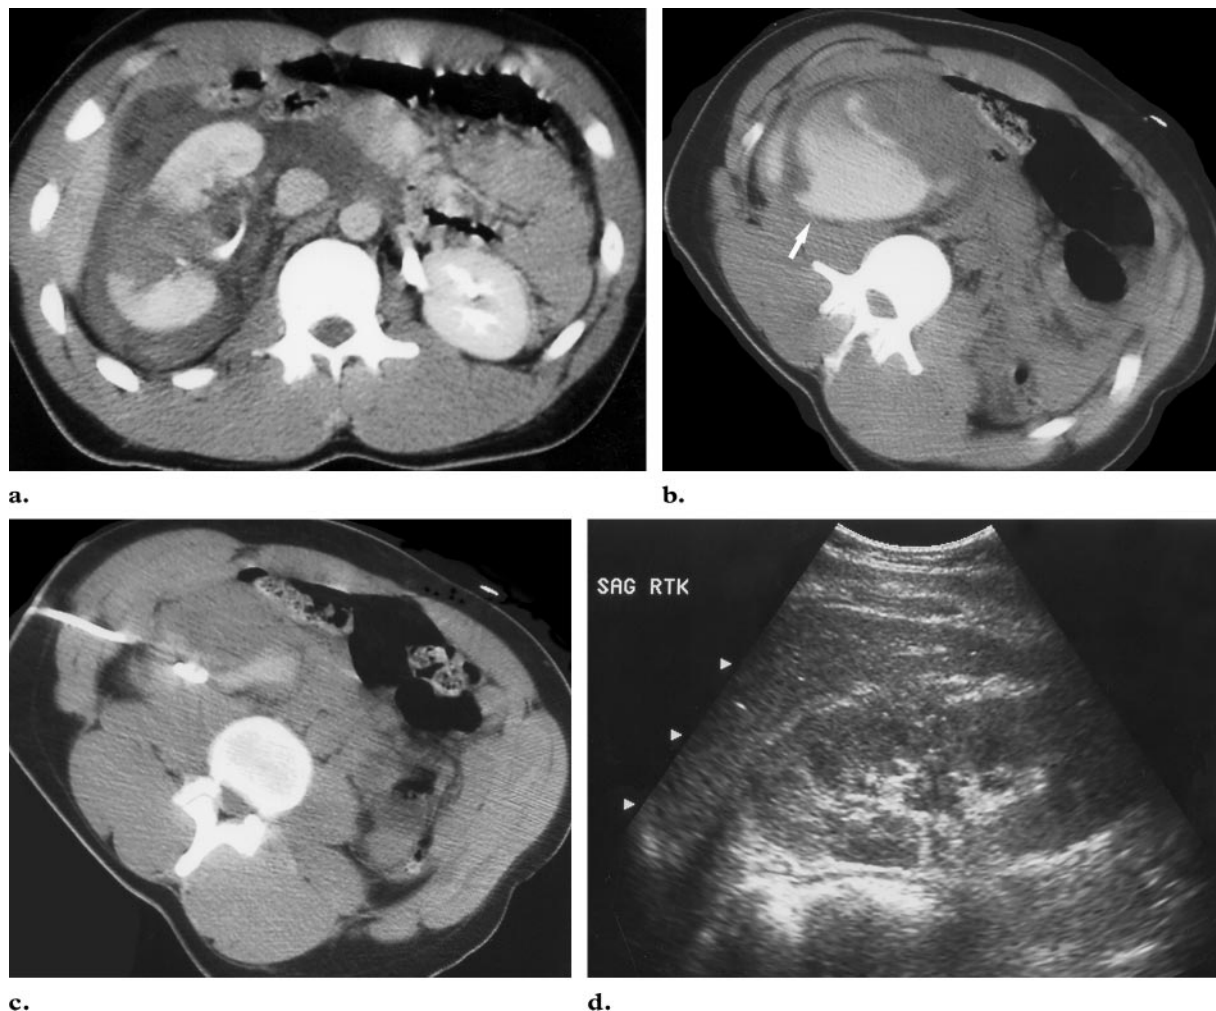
Renal urine leak and urinoma in a 20-year-old man who sustained right renal trauma in a motor vehicle accident. (a) Contrast-enhanced CT scan shows a fracture of the right kidney and a surrounding perinephric urinoma. (b) Delayed phase CT scan obtained 1 week later shows a persistent large perinephric urinoma. Note the high-attenuation contrast material in the dependent portion of the collection (arrow), a finding that indicates active leakage of enhanced urine. The patient developed progressive abdominal pain with initial conservative treatment, and a percutaneous urinoma drainage catheter was placed under US guidance. (c) CT scan obtained after percutaneous drainage of the perinephric urinoma helps confirm optimal placement of the drainage catheter. (d) Sagittal US image obtained 4 weeks after urinoma drainage catheter placement demonstrates complete resolution of the perinephric urinoma and continued healing of the right renal fracture.
